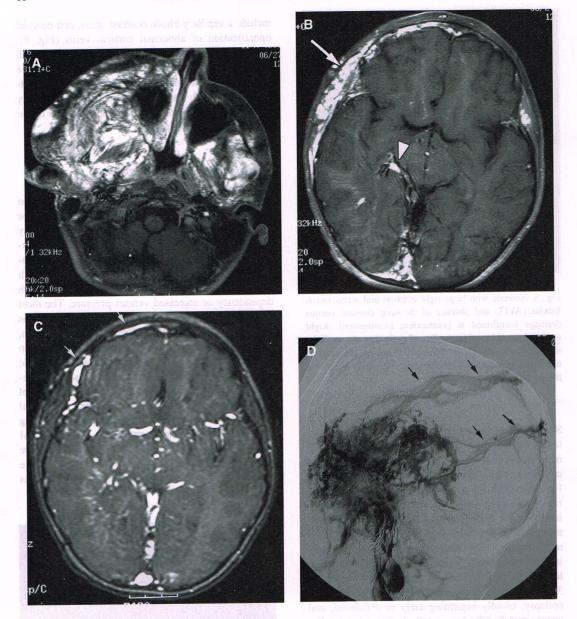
Diffuse bilateral cervicofacial venous malformation (VM) with DVA, calvarial VM, and sinus pericranii. (A) Axial T1-weighted MR image post-gadolinium shows diffuse enhancing soft-tissue masses and abnormal enhancement of the zygoma. (B) Postgadolinium axial T1-weighted MR image through the midbrain shows abnormal enhancement of the right frontoparietal calvarium (arrow), a right perimesencephalic DVA (arrowhead), and abnormal signal in the torcular. (C) Gradient echo MR image confirms that the enhancing areas in the calvarium seen in Fig. 7B are high flow channels (arrows) (D) Direct contrast injection into the VM in the right temple, digital subtraction, lateral projection, shows drainage in irregular intraosseous channels (arrows) that communicate with the superior sagittal sinus.
